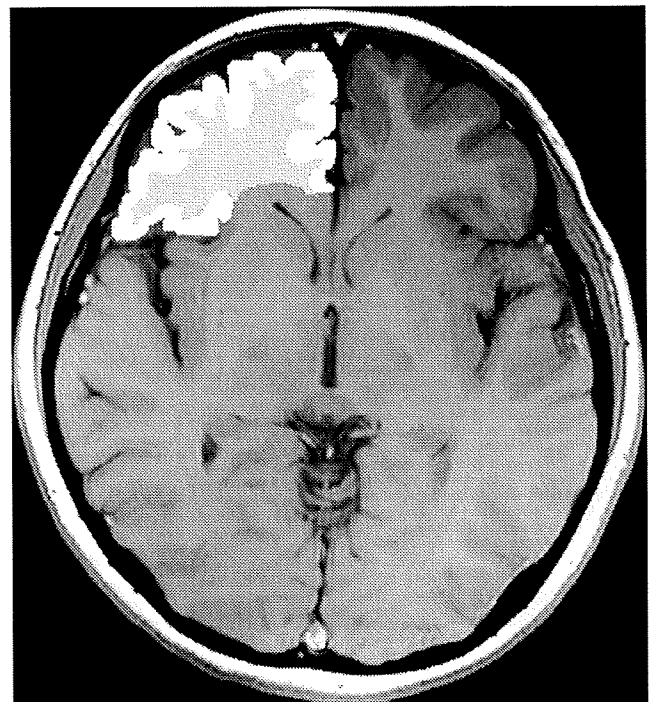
Representative image of a region-of-interest (ROI) on spin-echo T1-weighted imaging. Areas of gray matter and white matter in the frontal lobes were selected as ROIs.
